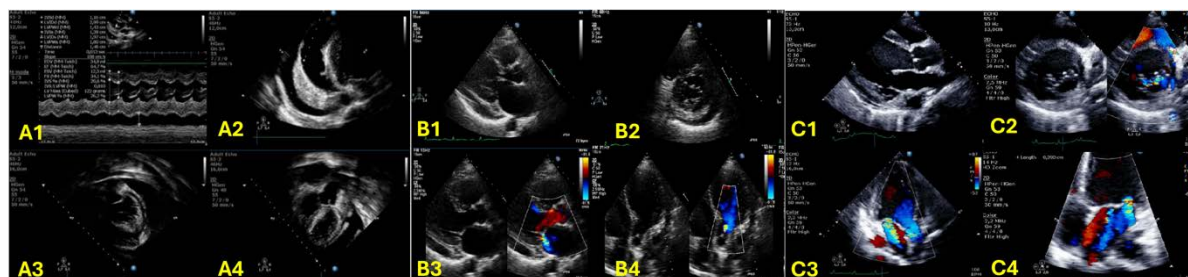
Transthoracic echocardiography showed three different cardiac manifestations in SLE: Fig A1-4 showed large pericardial effusions with normal cardiac functions and valves; Fig B1-4 showed mild pericardial effusion, thickened leaflets causing mild MR, and mild AR; Fig C1-4 showed LV dilation, markedly reduced LV systolic function (LVEF 28%), moderate MR, and thick leaflets with small nodules at the tip of AML
